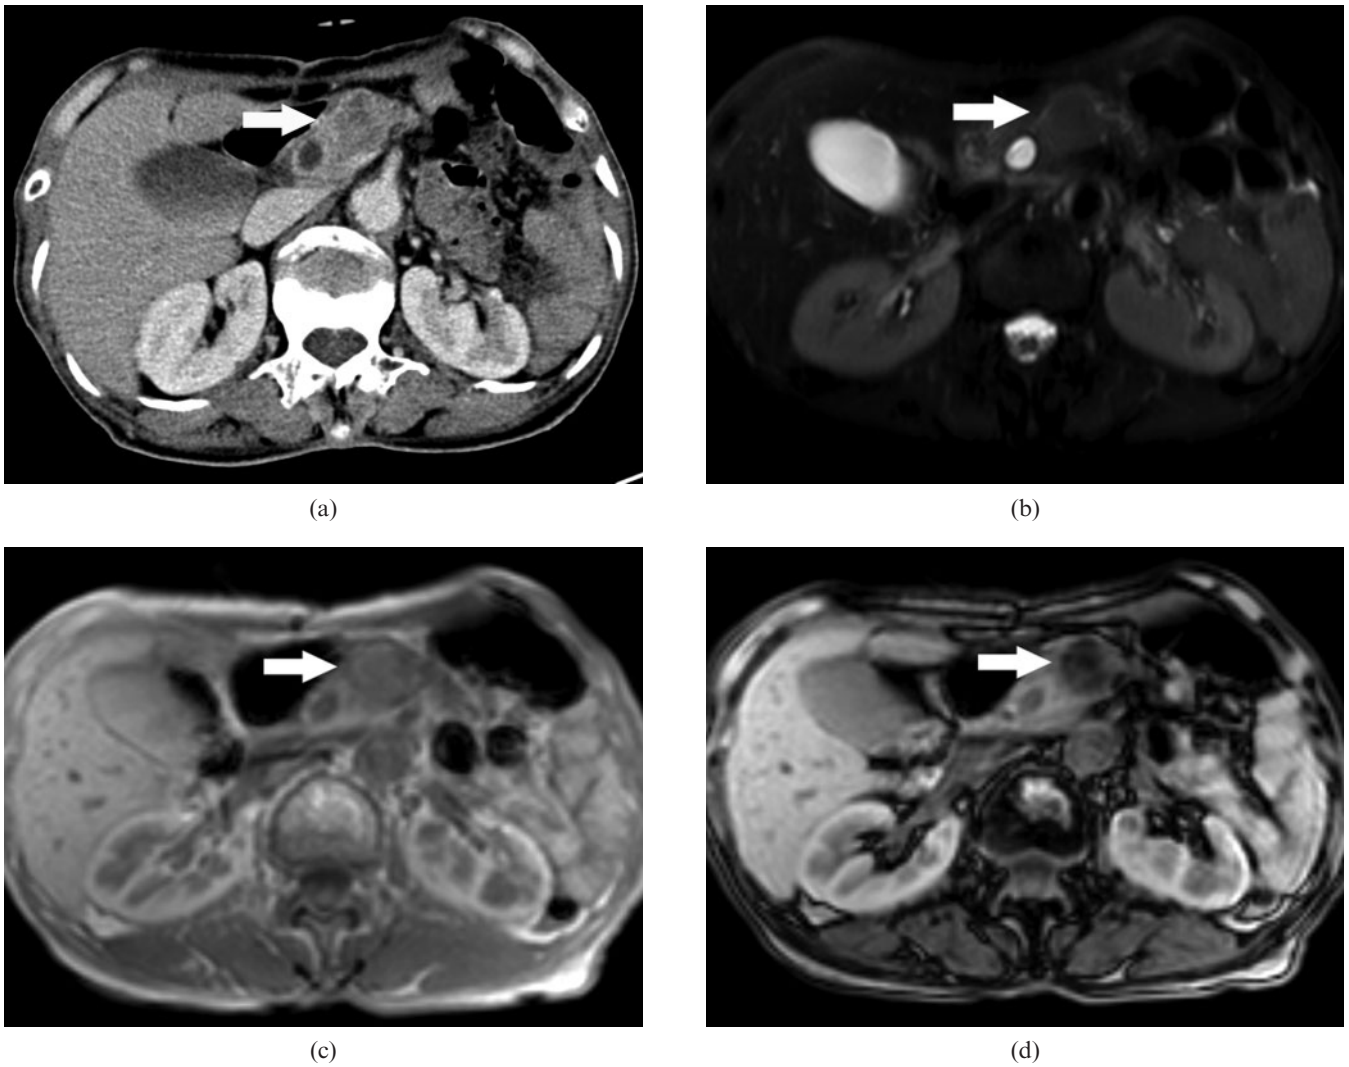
A 72-year-old female. (a) Contrast-enhanced CT showing a mass in the neck of the pancreas, which had less intense enhancement than the pancreas. (b) Axial T_2 weighted MRI with fat suppression showed low signal intensity in this mass. (c) In-phase and (d) out-of-phase MRI showing a fat component in this mass.
